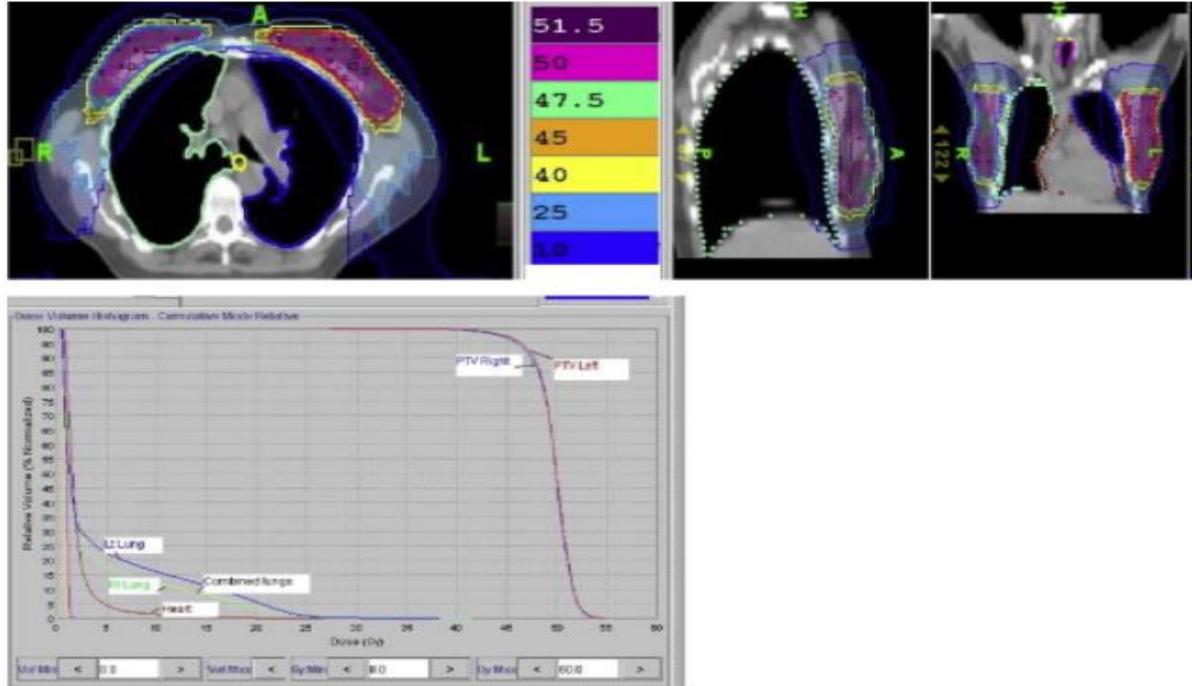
Computed tomography in axial plane (left panel) and reconstructed coronal computed tomography showing superimposed isodosimetry of the bilateral breast radiotherapy plan. The colour code represents the total dose to be received (Gy). The lower panel shows the dose volume histogram of the planning target volume and the organs at risk.
